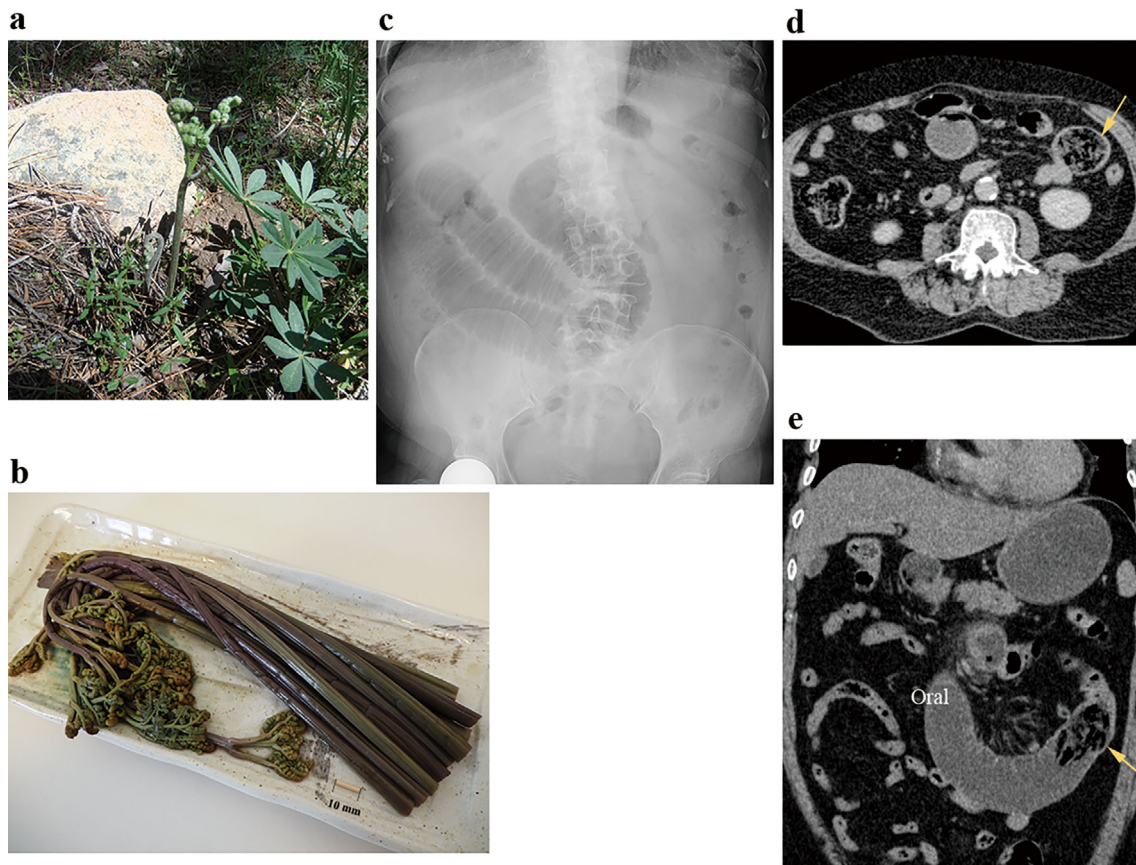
a Bracken (*Pteridium aquilinum*), also known as eagle fern or *Warabi*, is a species of fern in the family Dennstaedtiaceae. Bracken is a wild vegetable that grows in grasslands, valleys, and the wilderness. In early spring, bracken produces fist-shaped sprouts that are edible. Bracken is widely eaten in Japan, China, and Korea. After removing the strong lye with baking soda, bracken is eaten as a boiled vegetable, pickled, marinated, or as an ingredient in miso soup. b Marinated bracken in soy sauce. c Abdominal X-ray showed a dilated small intestine. d, e Contrast-enhanced computed tomography revealed an air-filled foreign body (arrow) in the jejunum, with dilatation and fluid collection in the oral intestine.
